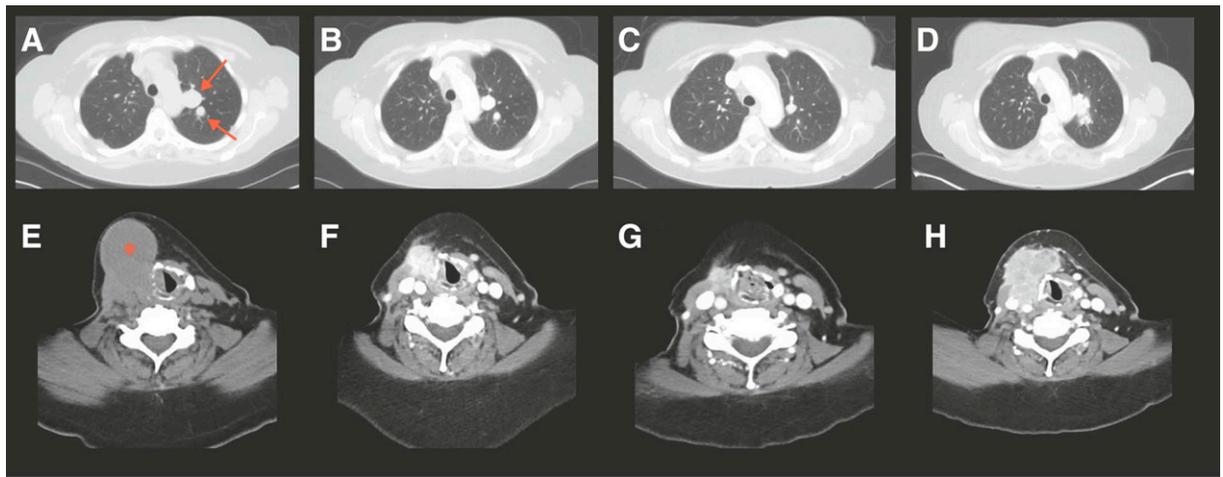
Clinical response to combined BRAF and MEK inhibition. Representative images are from chest CT (A–D) and neck CT (E–H) of the target lesions in the left upper lobe (arrows) and right thyroid bed (asterisk) at baseline (A, E), after 2 cycles (B, F), after 10 cycles (C, G), and at progressive disease after 20 cycles (D, H).
